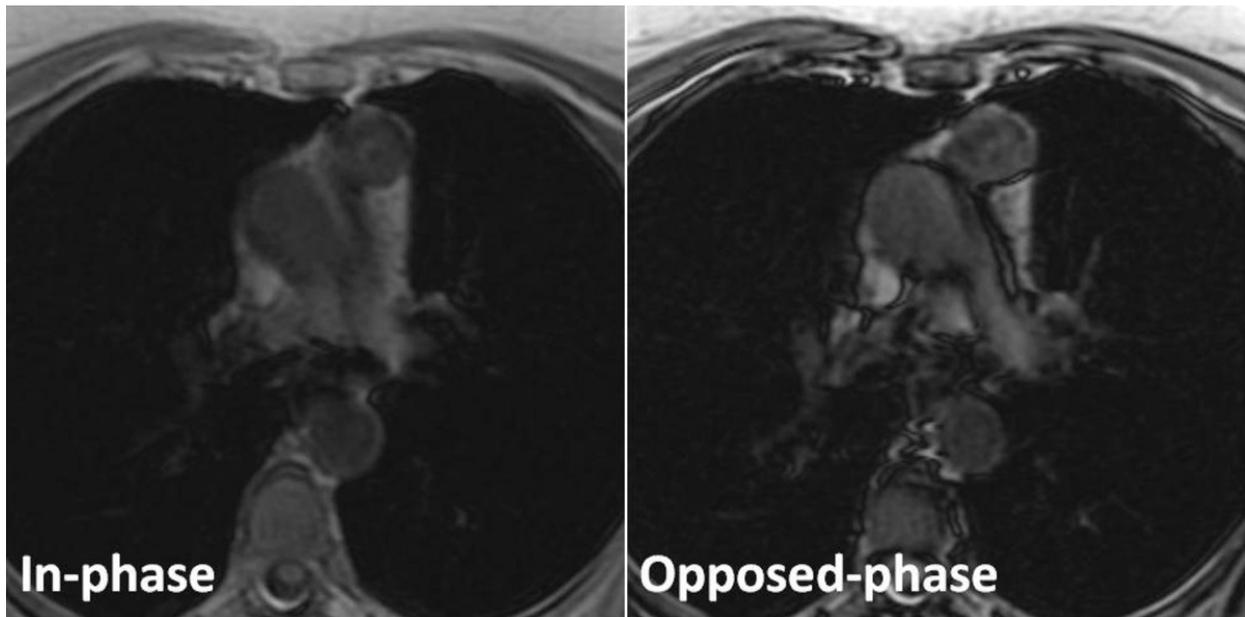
Thymoma in a 65-year-old woman with myasthenia gravis. Transverse in-phase (155/4.6) and opposed-phase (155/2.1) gradient-echo T1-weighted MR images demonstrate no change in signal intensity of the lesion on the opposed-phase image relative to the in-phase image. The CSR is 1.010.
